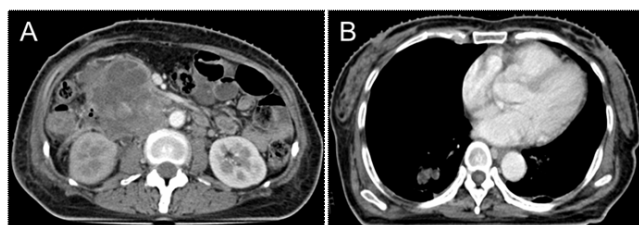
Contrast-enhanced computed tomography of the abdomen and chest. (A) retroperitoneal tumor with TE in the IVC (arrowhead); (B) pulmonary TE (arrow).
